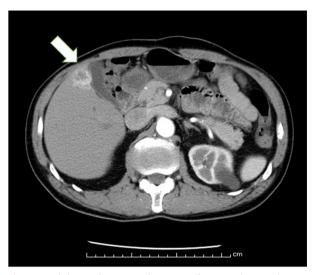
Abdominal computed tomography scan showing liver metastasis.
